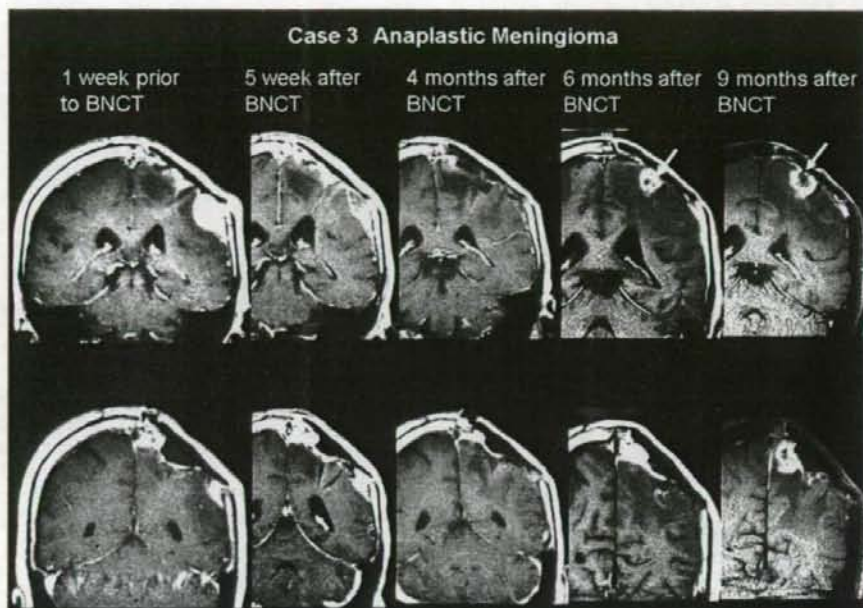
Gd-enhanced coronal MRI scans of Patient 3, who had an anaplastic meningioma. A growing tumor was identified on the left frontoparietal convexity with subcutaneous bulging, just before BNCT. In addition, a small Gd-enhanced mass was identified close to the SSS. In the follow-up images, the main mass gradually become smaller, and it cannot be seen in the MRI scan taken 4 months after BNCT, whereas the concomitant mass close to the SSS became large after transient shrinkage. The relative volumes of the lesion close to the SSS compared with the initial volume are 122, 48.3, 75.4, and 144.2% at 5 weeks, 4 months, 6 months, and 9 months after BNCT, respectively. The arrows indicate the newly appeared lesions, which were proven to be the result of radiation necrosis on craniotomy.
